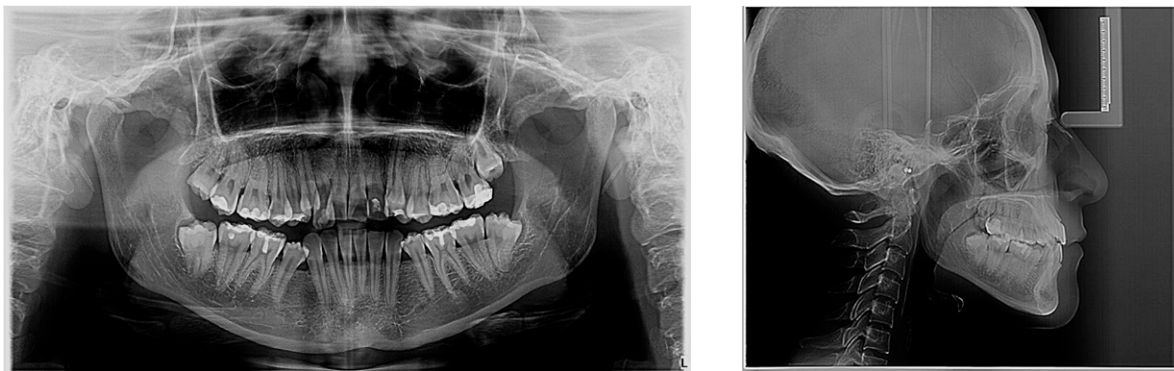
Initial orthodontic studies, from left to right, orthopantomography and lateral head film.
